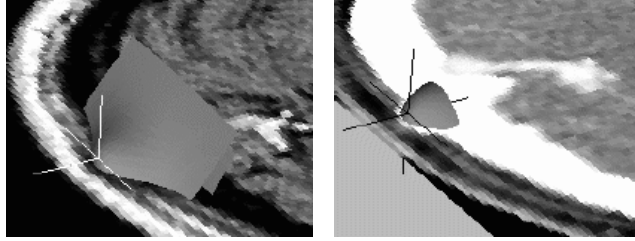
3D contour plots of the fitted intensity models for the left and right frontal horn within an MR image (Woho). The result is shown for two different slices of the original data. The marked axes indicate the estimated landmark positions.
